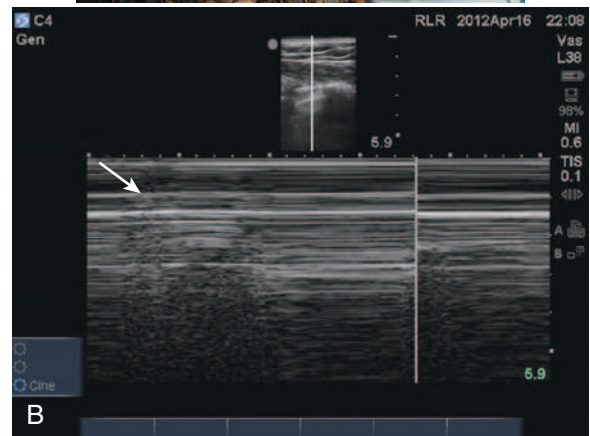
A, Portable ultrasound devices are easily transported for rapid assessment of physiologic and anatomic parameters. B, Example of pneumothorax on ultrasound.
